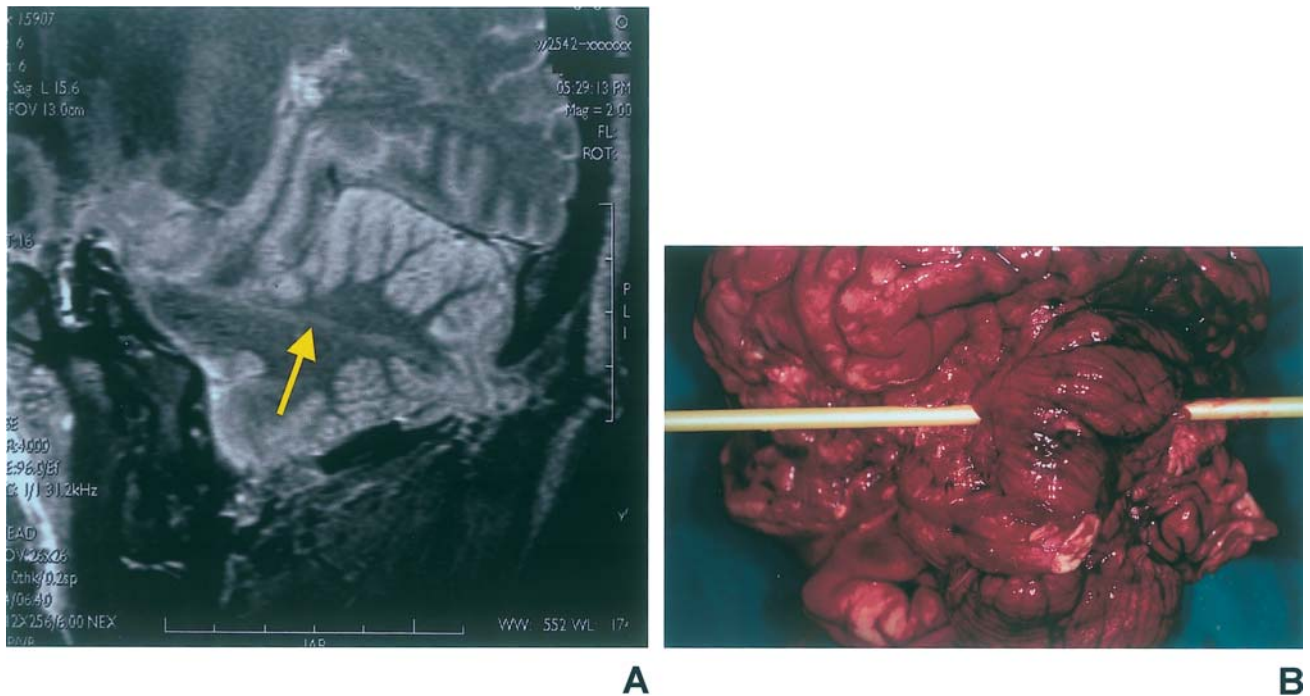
Gunshot wound (Case 022): (a) sagittal T2-weighted fast SE MR image (4000/96) showing the bullet track (arrow) through the cerebellum; (b) same bullet track marked with a probe during autopsy.
